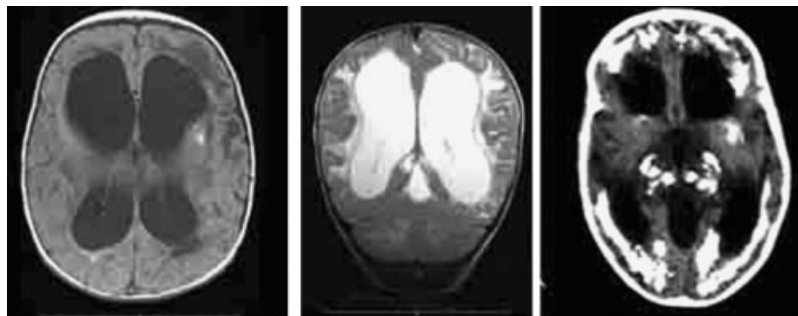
Patient 6: MRI showing features of a non-progressive hydrocephalus and extensive abnormalities of the white matter. Additionally, CT (right) reveals widespread calcifications.
